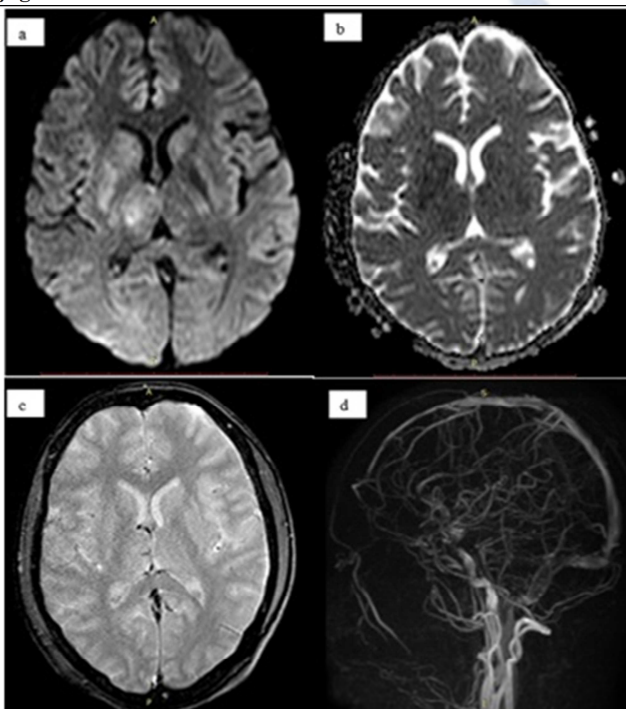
A 32years old female patient demonstrating multifocal DWI (a) high signal intensities involving right caudate, lentiform nucleus and right thalamus which are showing corresponding restriction on ADC (b) and no blooming on gradient sequence (c). Sagittal TOF MRV (d) showing thrombosis of internal cerebral veins, vein of Galen, straight sinus, left transverse sinus, sigmoid sinus and extending into left IJV
